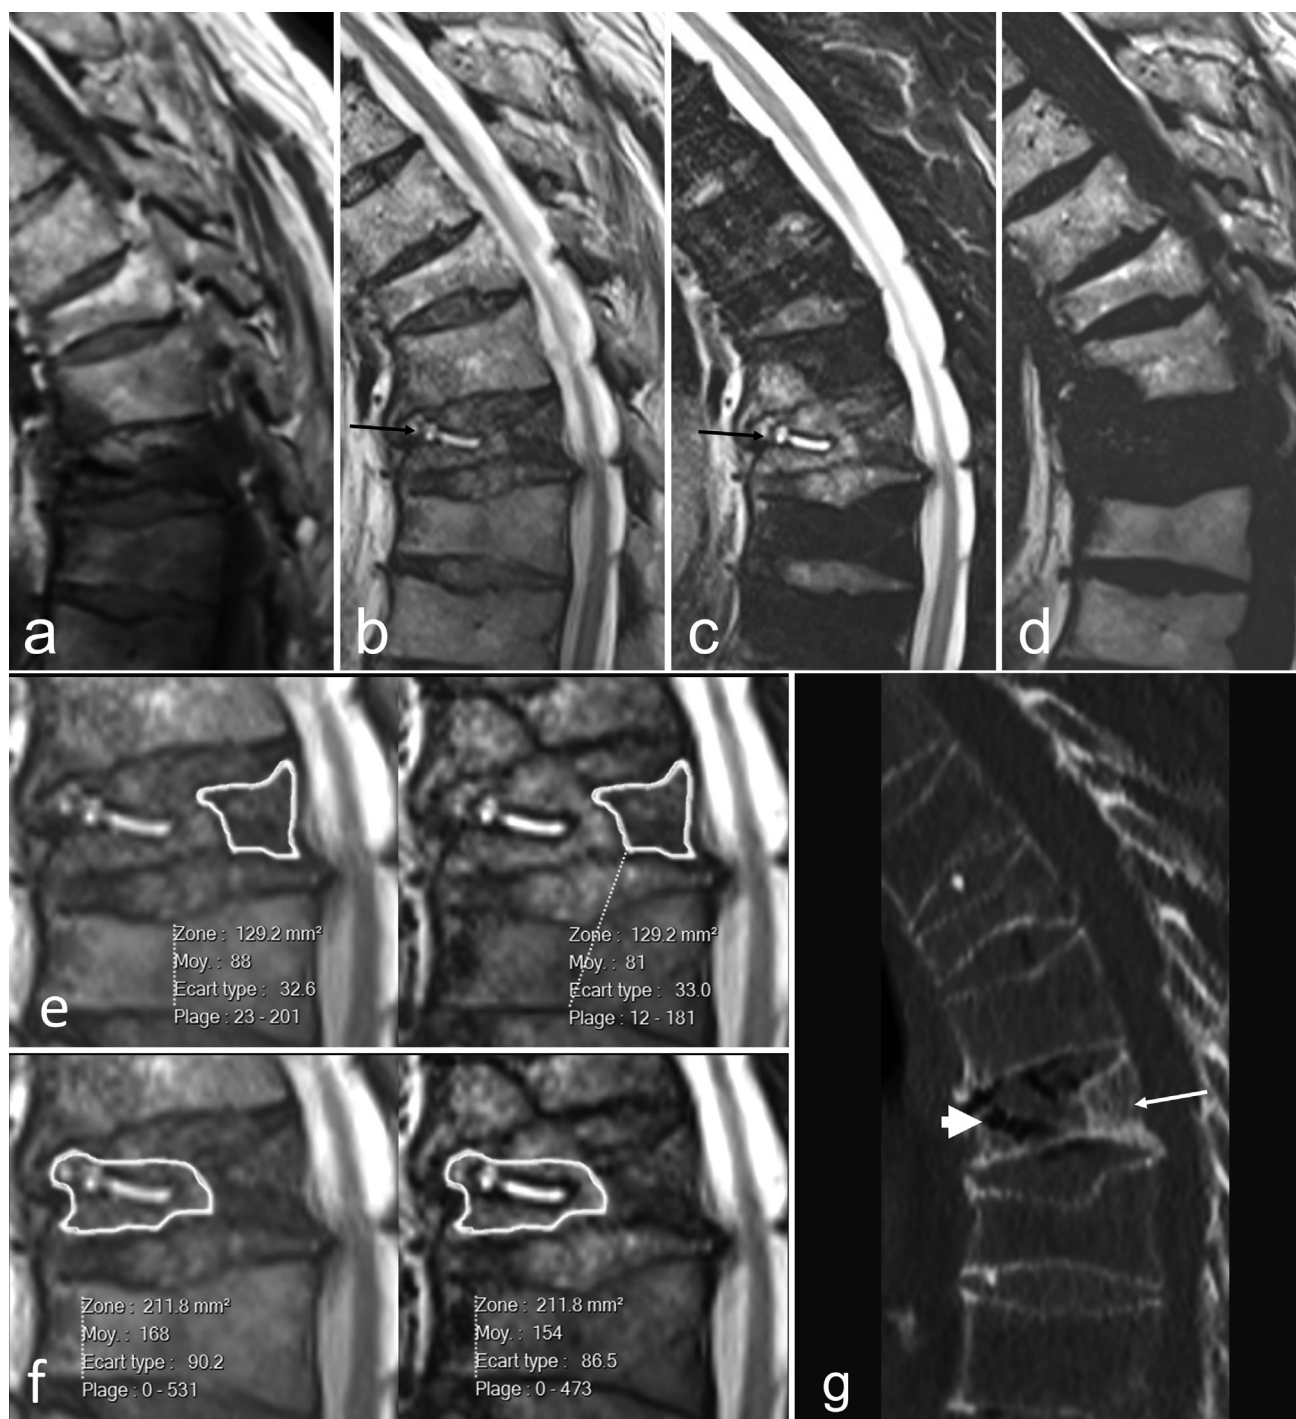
An 82-year-old man with nontraumatic back pain. Sagittal (a) T1-weighted, (b) in-phase, (c) water-only, and (d) fat-only T2-weighted Dixon images show a recent vertebral compression fracture (VCF) of T12 with an intravertebral horizontal fluid-filled cleft (b, c, arrow) in favor of a benign VCF. However, the vertebral body did not show any residual fat (d), and there was no signal drop on out-of-phase images (e), suggestive of a marrow-replacing lesion. In view of the discordance, a vertebral biopsy was performed (not shown) that was negative for malignancy. (g) Sagittal reformat of computed tomography (CT) images show sclerotic changes in the posterior third of the vertebral body (arrow) and gas-containing cleft (arrowhead) as sources of false-positive findings on quantitative analysis of Dixon imaging. Follow-up fluorodeoxyglucose positron emission tomography/CT was negative for malignancy (not shown). Of importance, regions of interest should exclude fluid-filled regions to avoid false-positive results (f).
